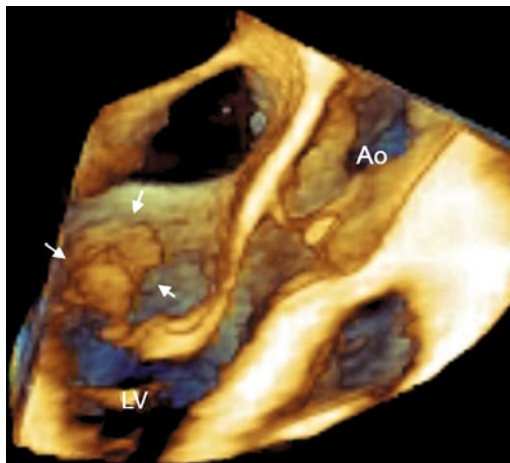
Large-scale endocarditic vegetation (arrows). Image obtained with a transesophageal three-dimensional approach. *Ao* aorta, *LV* left ventricle
